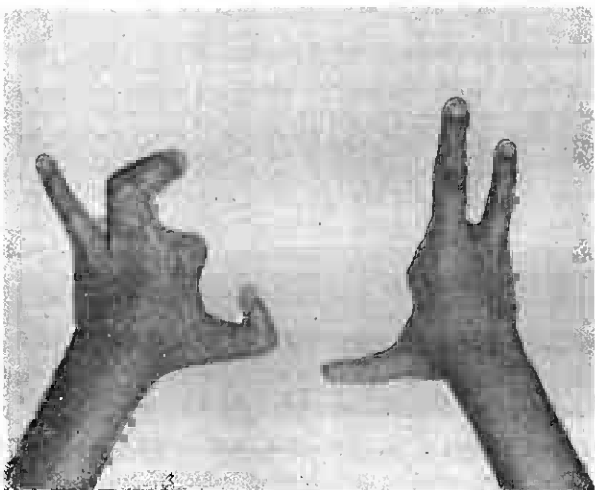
The hands of Case III. An X-ray of the left hand showed a fusion of the phalanges of the middle and ring fingers.
